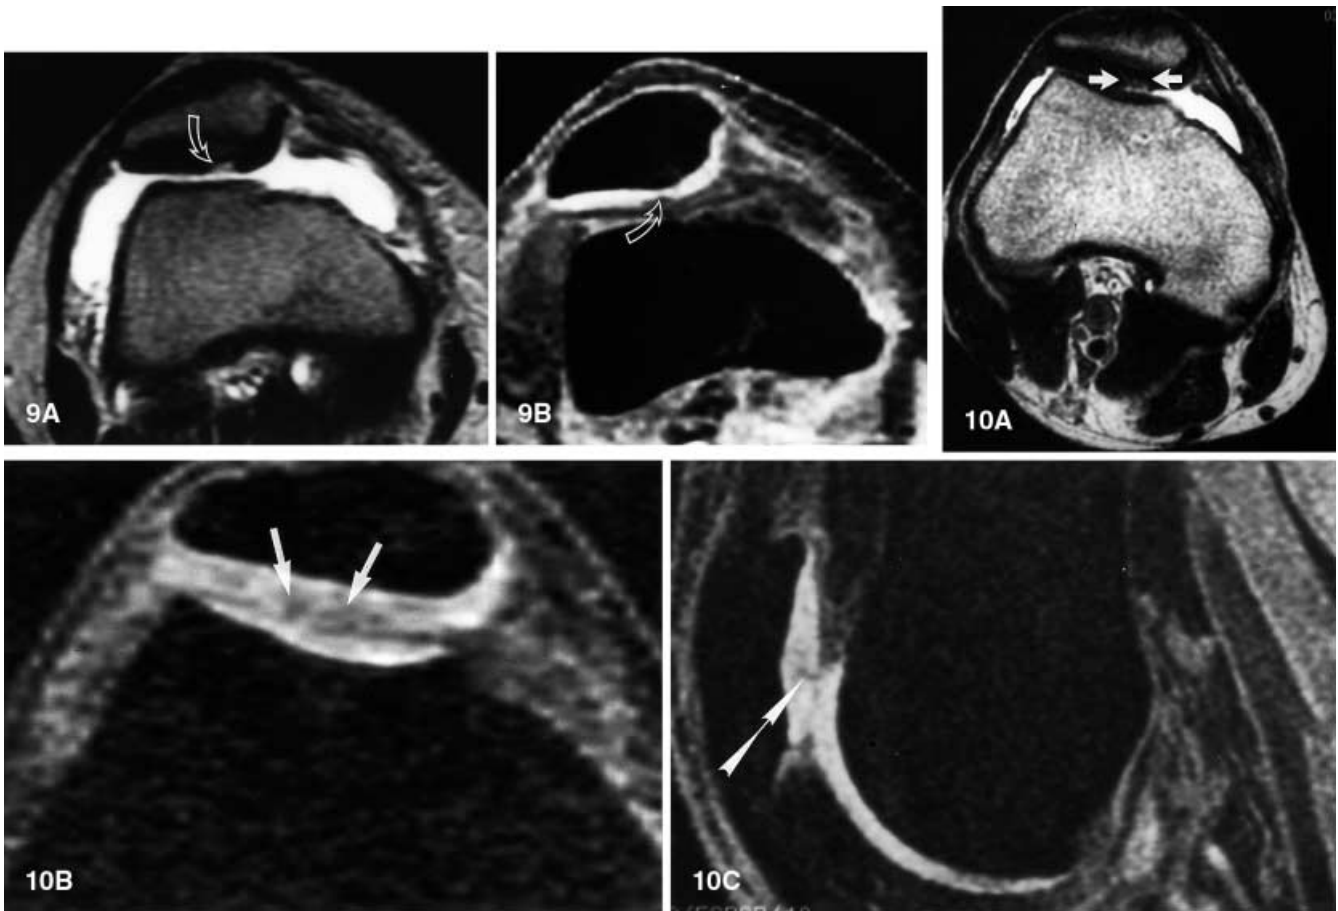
Articular derangement that is equally apparent on intermediate-weighted fast spin-echo and spoiled gradient-echo images. A Axial T2-weighted fast spin-echo image (4000/91, TR ms/TE ms) demonstrates localized increased signal (*arrow*) along the lateral patellar facet. B Axial reformatted image of fat-suppressed three-dimensional spoiled gradient-echo MR images acquired in the sagittal plane (32/8; flip angle, 40°) shows a contour defect (*arrow*) at the lateral patellar facet
